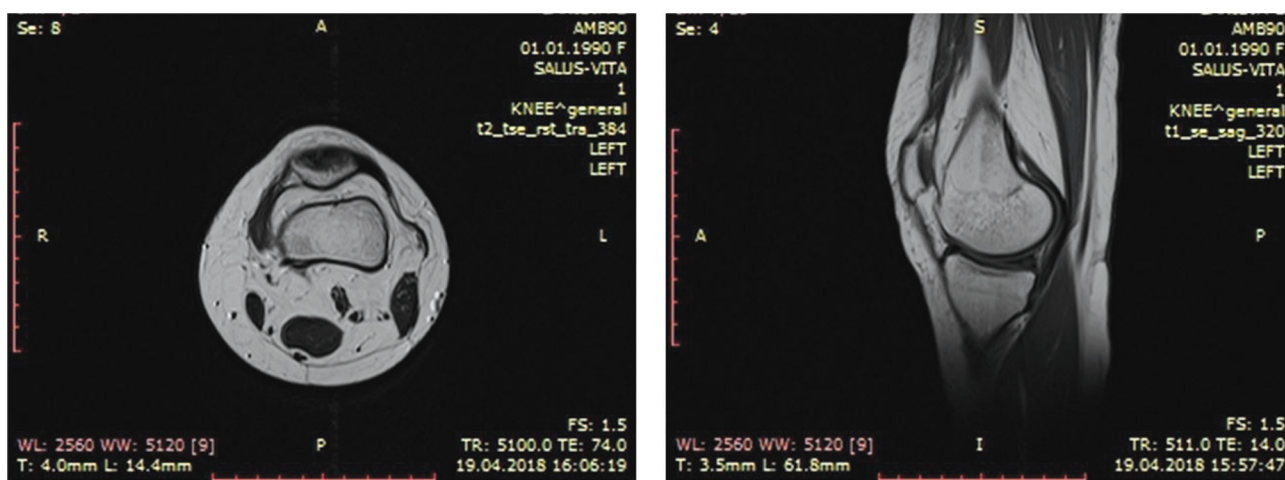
MRI scans showing left knee PMPP
